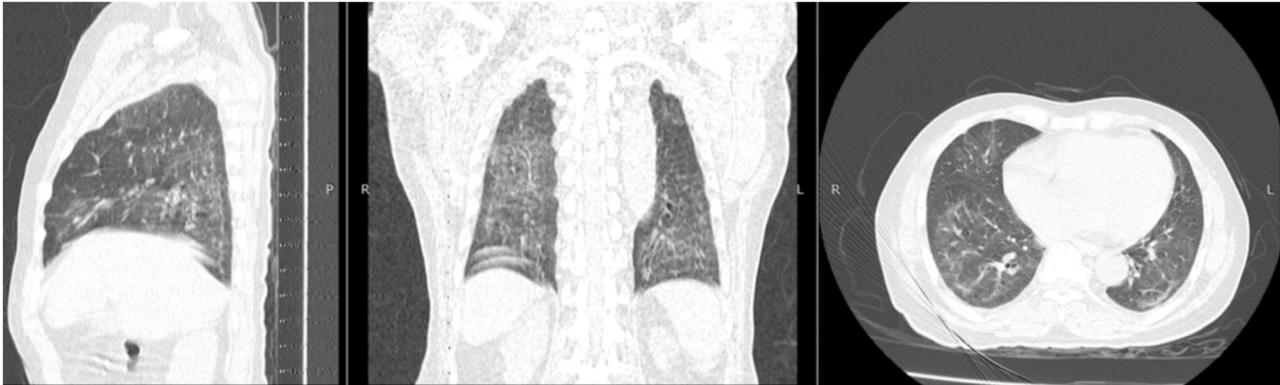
Chest CT images of a 48-year-old male, forty-four days post covid from symptom onset with a score of 16 (severe), showed a parenchymal band in both lung and traction bronchiectasis and bronchiolectasis in the apical segment of the right upper lobe and posterobasal segment of the right lower lobe.
